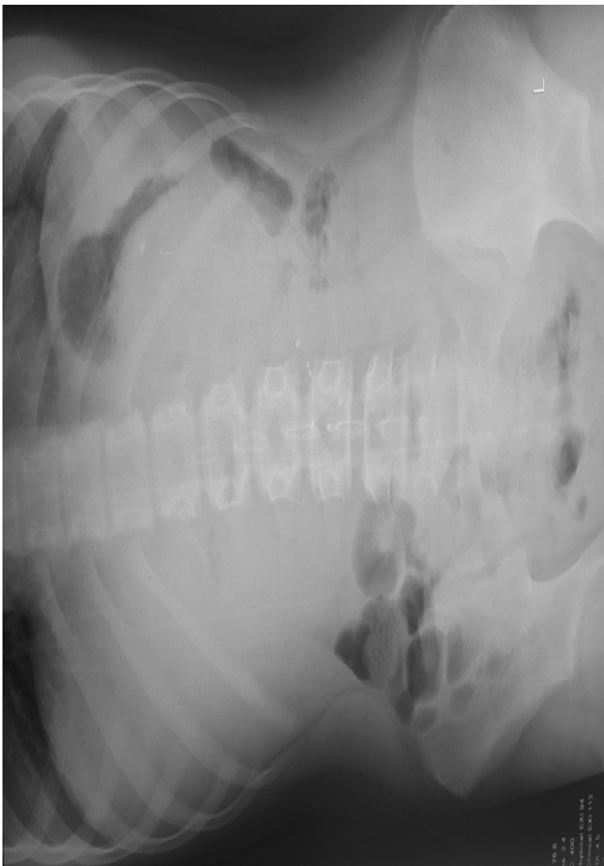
Abdominal radiograph showing large intraluminal filling defect with mottled lucencies, staples, and a few metallic foreign bodies.
